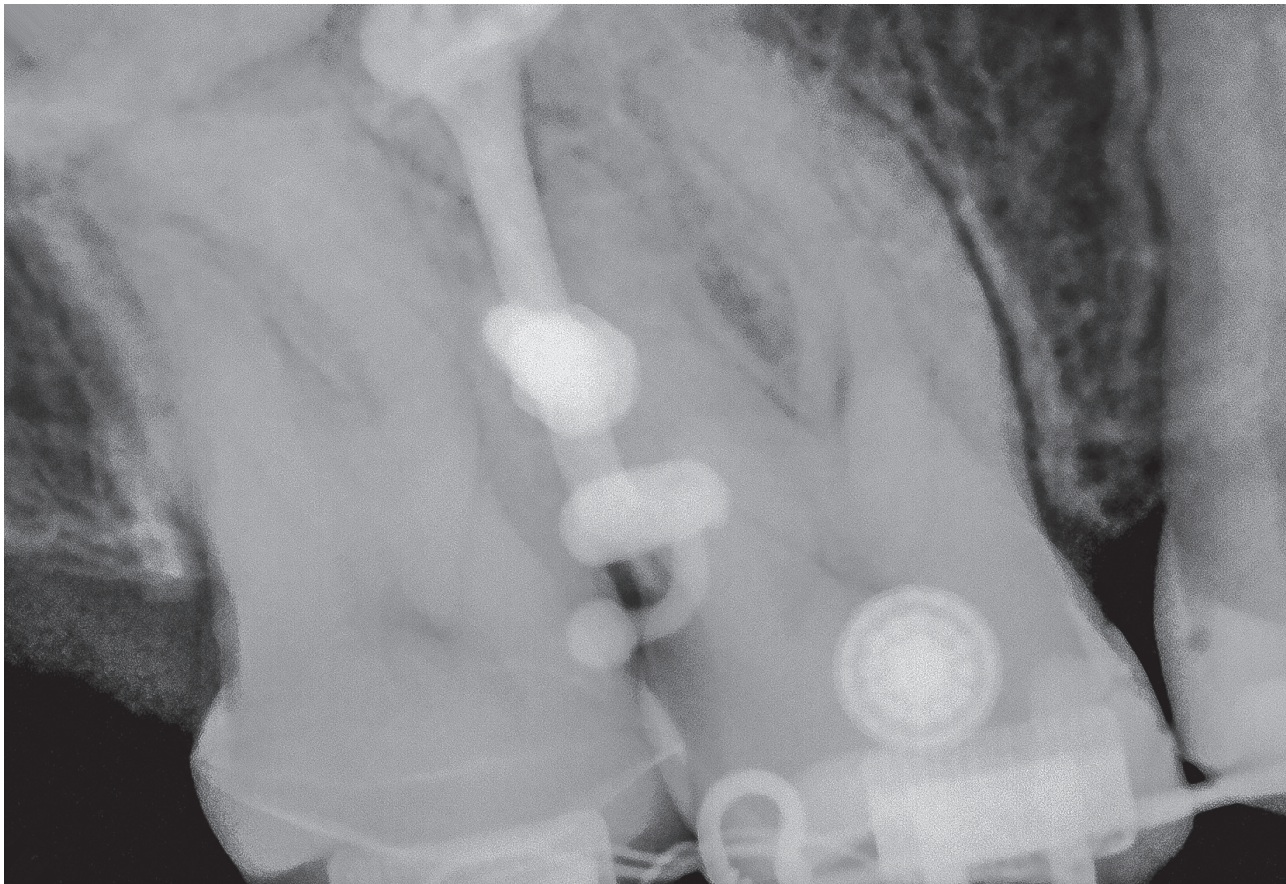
Radiograph of unit 17 after 2 years.
